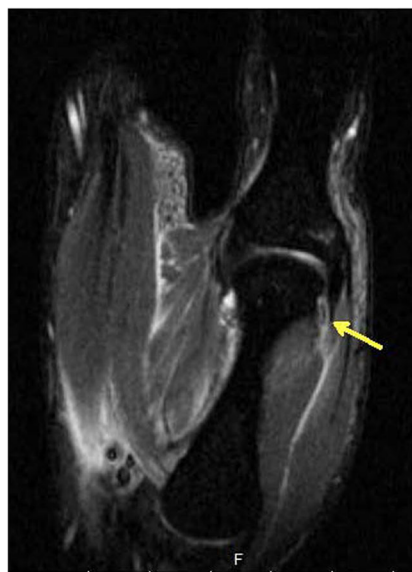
T2 weighted coronal MRI of the thumb MP joint demonstrating a tear of the radial collateral ligament off the metacarpal head
